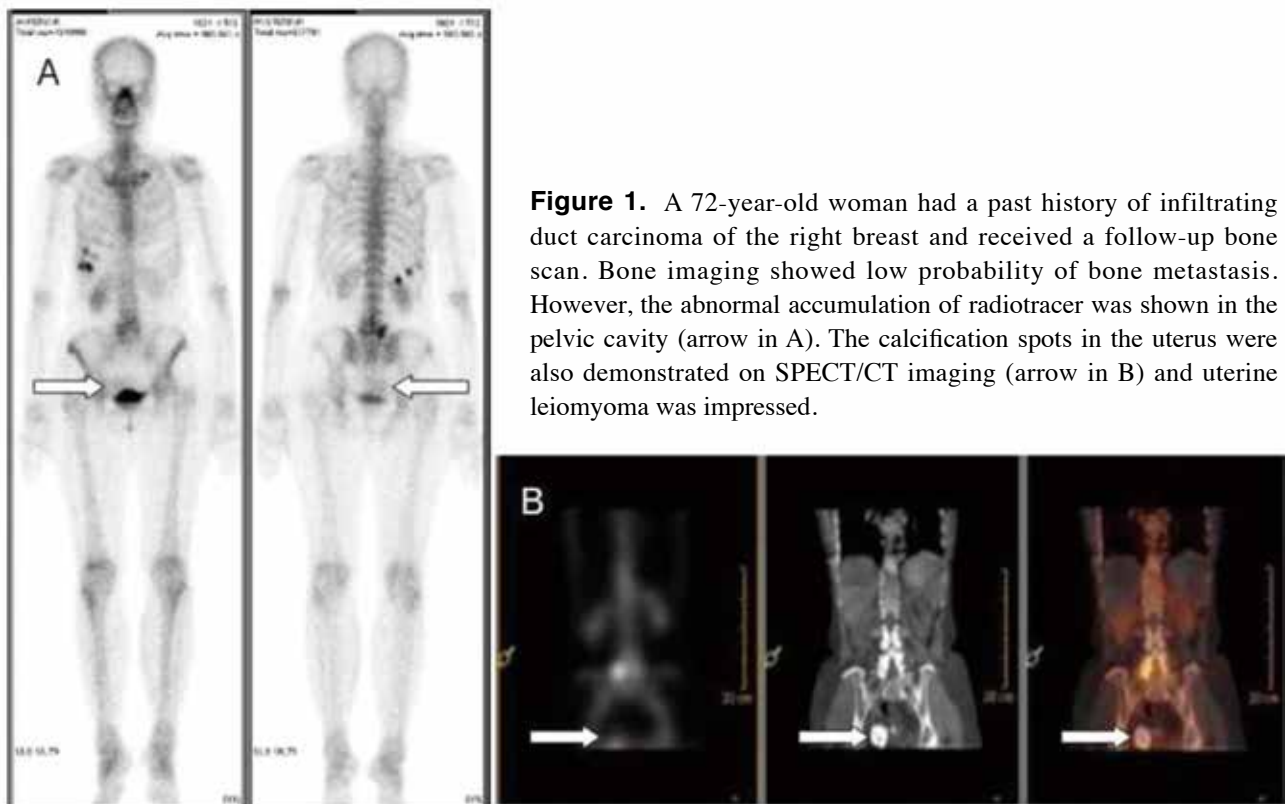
A 72-year-old woman had a past history of infiltrating duct carcinoma of the right breast and received a follow-up bone scan. Bone imaging showed low probability of bone metastasis. However, the abnormal accumulation of radiotracer was shown in the pelvic cavity (arrow in A). The calcification spots in the uterus were also demonstrated on SPECT/CT imaging (arrow in B) and uterine leiomyoma was impressed.
